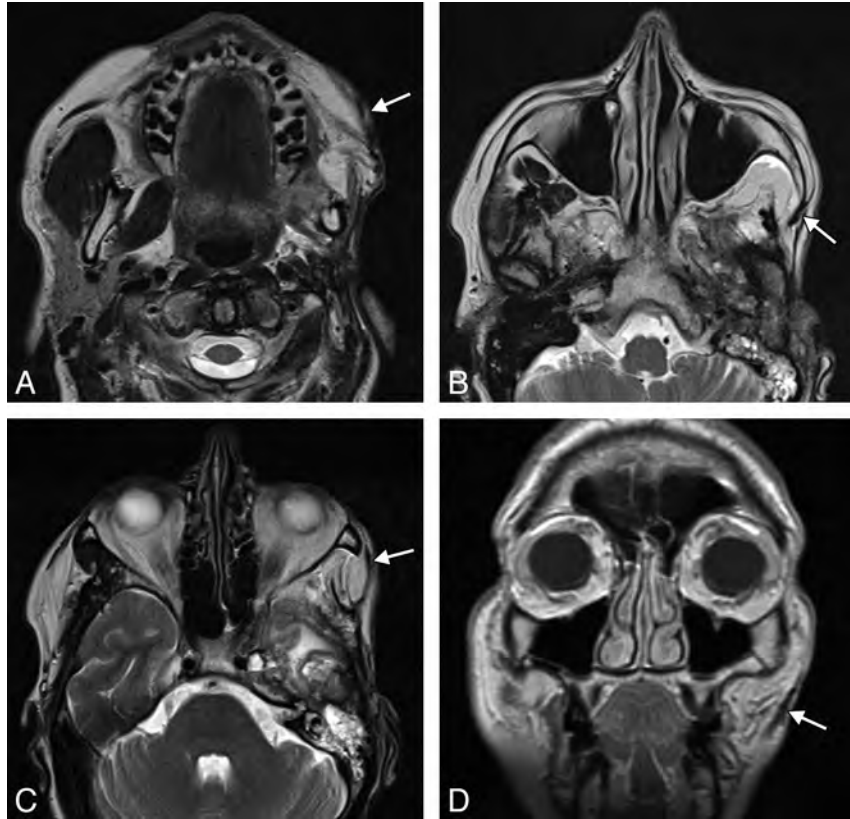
Temporalis flap. Axial T2 MR imaging (A–C) and coronal T1 MR imaging (D) show that the left temporalis muscle with the overlying fascia (*arrows*) is directed retrograde from the temporal fossa to the orbicularis oris.
